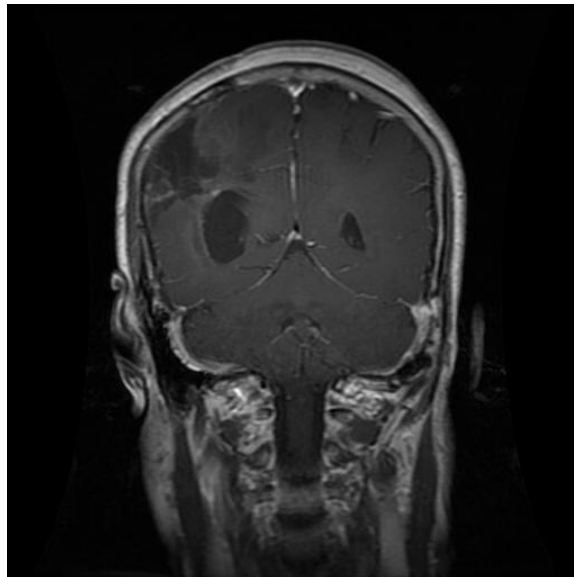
DL can be used to detect the presence of brain cancer in this MRI [4]
